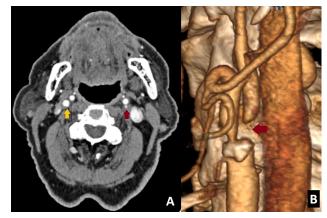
Axial CT angiography (A) and 3D reconstruction (B) demonstrate critical stenosis of the left in-ternal carotid artery (red arrow – left internal carotid artery, yellow arrow – right internal ca-rotid artery).
